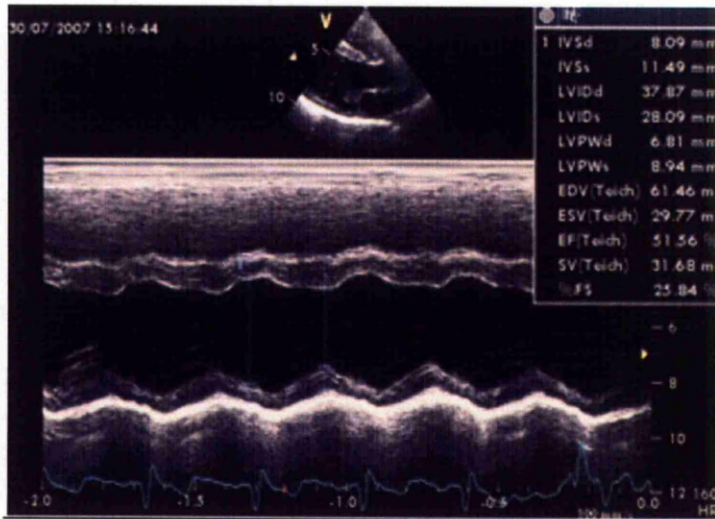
Echocardiographic M-mode recording to measure Fractional Shortening.
